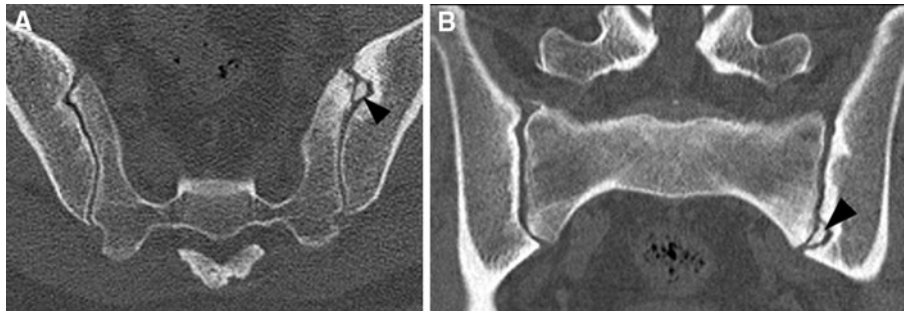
Axial (A) and coronal-reformatted (B) unenhanced CT images of the pelvis display a well-circumscribed osteochondral lesion (*arrowhead*) of the anterior portion of left SI joint. The
